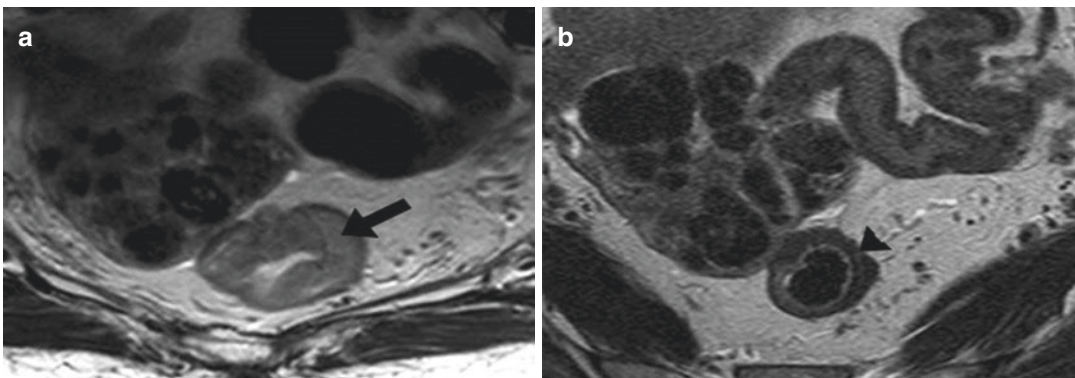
(a) Axial image of a pre-treatment rectal cancer. (b) Axial MRI image of post-treatment rectal cancer showing good response (mrTRG1)
